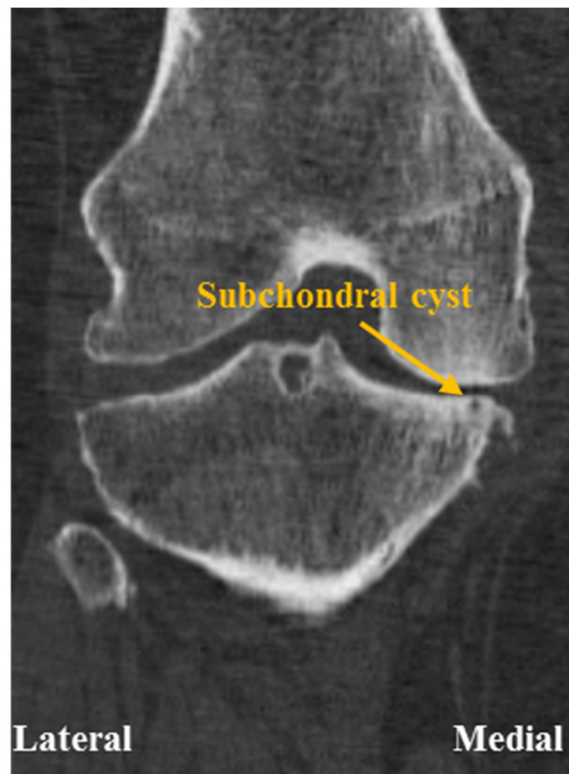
Coronal section of a CT image showing a medial cyst in the subchondral bone of the proximal tibia.
